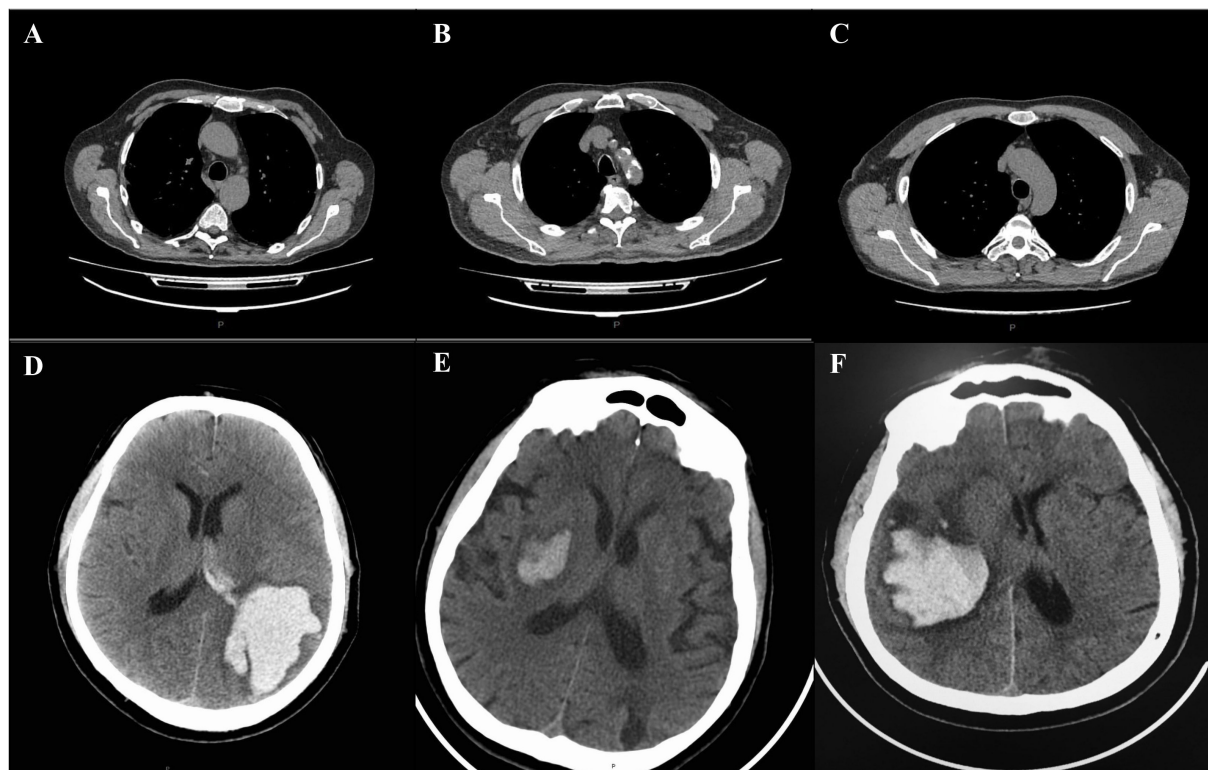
CT changes of lung and brain in patients with COVID-19 complicated with ICH (A–F). Chest and brain CT examination of patient 1 showing bilateral consolidations and ground-glass opacities of the lungs (A), and hemorrhage in the parietal-occipital region on the left with a breakthrough of blood into the ventricular system (D). Chest and brain CT examination of patient 2, showing diffuse bilateral ground-glass opacities involving both lungs (B) and hemorrhage in the projection of the basal ganglia on the right (E). Chest and brain CT examination of patient 3, demonstrating bilateral ground-glass opacities (C) and hemorrhage in the projection of the basal ganglia on the right with a breakthrough into the ventricular system (F). P = posterior.
